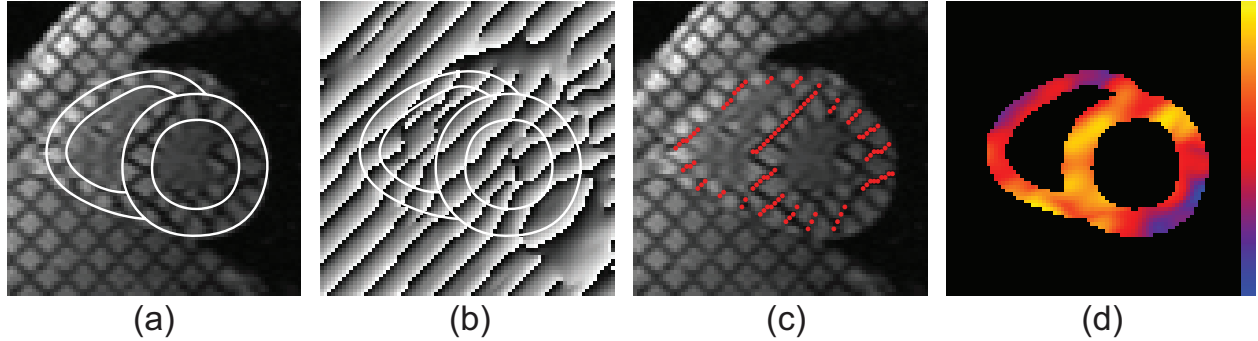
Example of feature extraction. White borders are myocardial contours. (a) is the tagged MR image at end-systole. (b) is the phase map computed after interpolation of the complex responses from the Gabor filter bank centered at $(0.1467, \pi/4)$. (c) shows the detected tag points using the phase map from (b). Only points within contours were displayed. (d) is the estimated tag frequency map using the optimal interpolated filter parameters. The frequency ranges from 0.13 pixel^{-1} (blue) to 0.18 pixel^{-1} (yellow).
